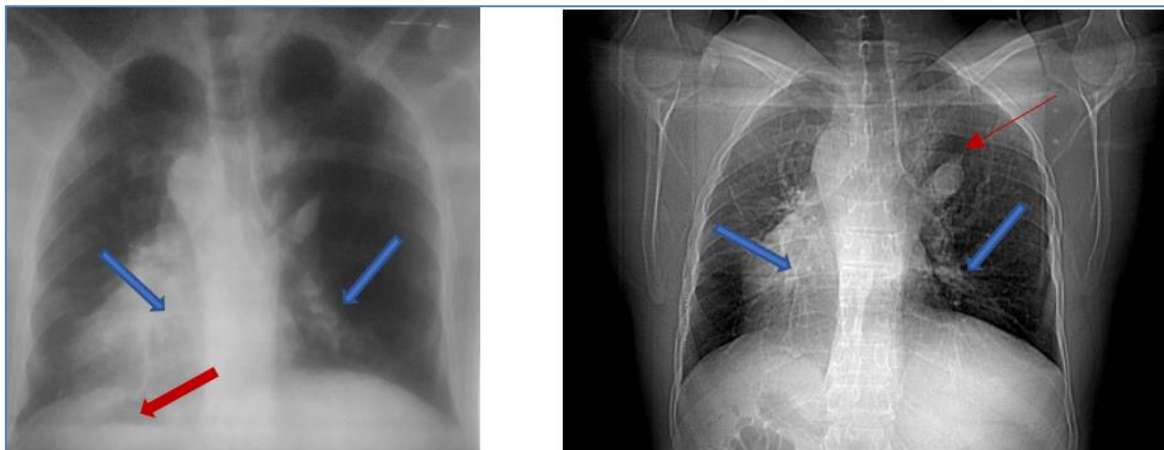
Frontal chest radiograph and scout View: dextrocardia, right aortic knob, bronchial syndrome with left basal lung condensation focus, associated with left juxta hilar rounded opacity surmounted by a thin linear opacity starting from the apex of the left lung parallel and outside the left edge of the mediastinum; inversion with a mirror position of the hepatic opacity on the left and the gastric air sac on the right.
